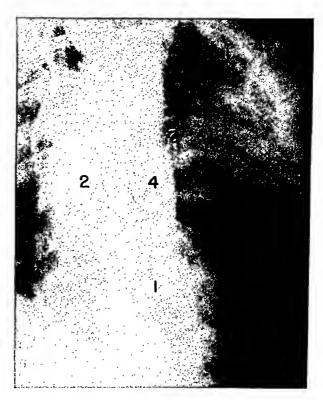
Postmortem roentgenogram, after opacification of heart and vessels, left oblique view. Retouched. The left ventricle (1), ascending aorta (2) and the stricture at the junction (3) of the aortic arch and the descending aorta are visible. The bulbous dilatation of the descending aorta (4) corresponds, in location and shape, to the displacement of the esophagus on the clinical roentgenogram.
